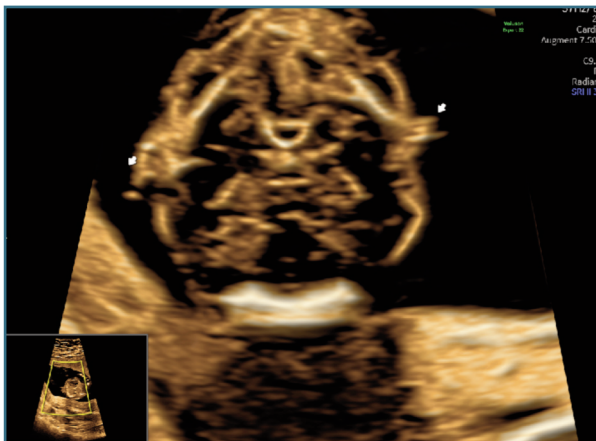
Ultrasonographic evaluation performed at 17 weeks and 6 days showing dysmorphic facial features (hypoplasia of the right ear).
